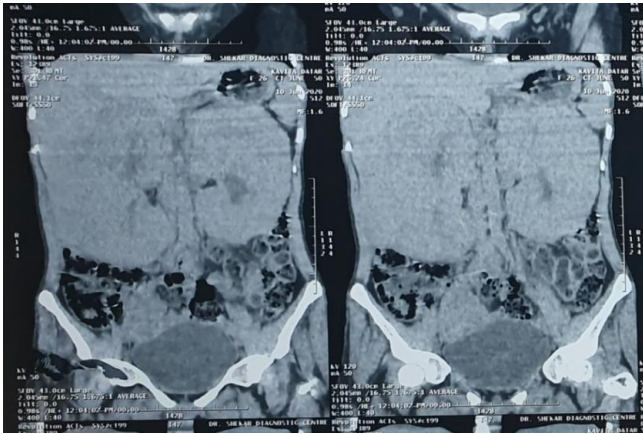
Bilateral massive Nephromegaly on CT Abdomen
